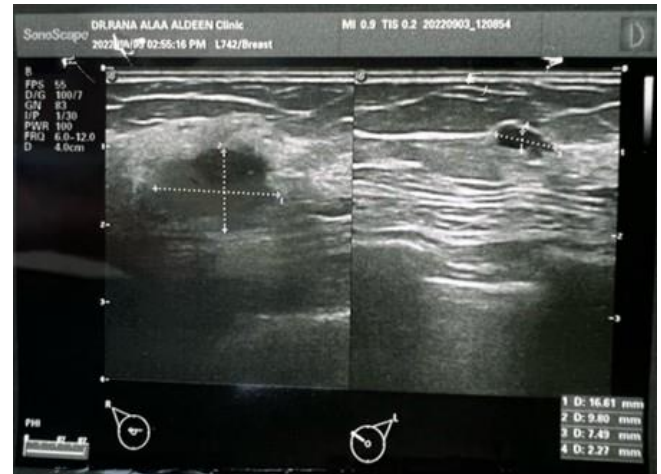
Breast ultrasonography findings. Breast ultrasonography image presenting specific features of interest: This image demonstrates: An irregular and ill-defined hypoechoic mass in the right breast, measuring 16.6 mm by 10 mm. The presence of internal tiny echogenic foci, indicative of calcifications. Notably, the mass is situated within the subareolar region.
